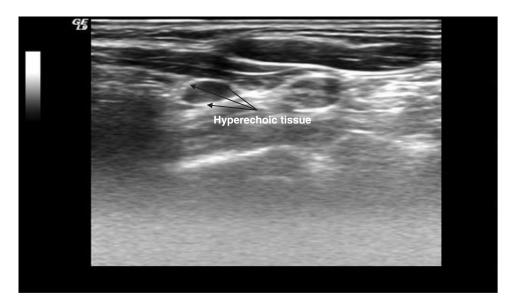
Ultrasound features after the first 'step': hyperechoic image all around the parathyroid adenoma.
